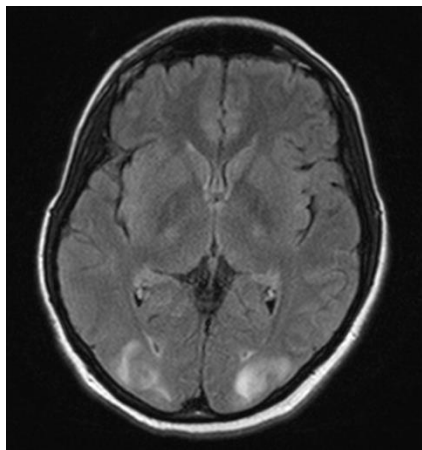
Multiple cortico-subcortical areas of FLAIR-weighted hyperintense signal involving the occipital lobes bilaterally in axial plane
